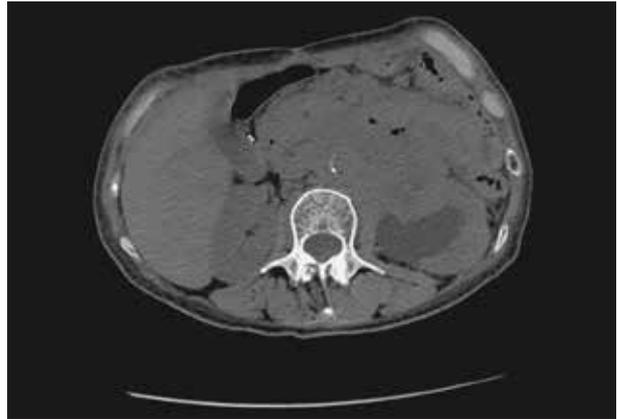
Case 1: Computed tomography scan, simple phase showing recurrence of the disease, with a retroperitoneal lymphatic conglomerate which invades left kidney and left ureter.
